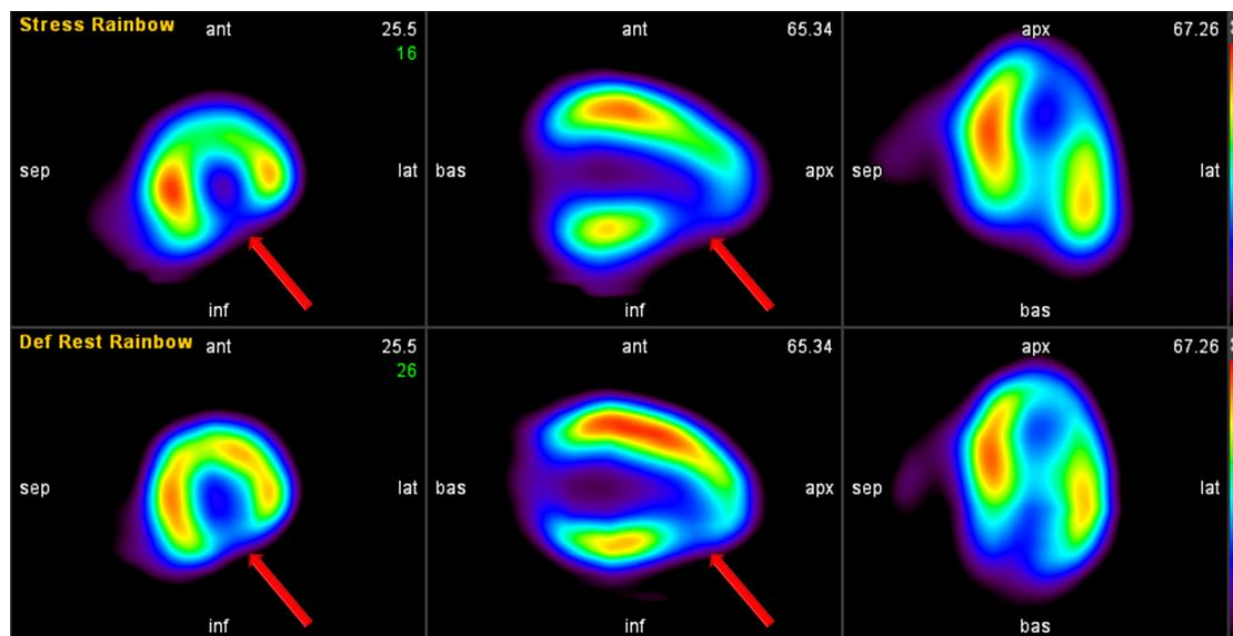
MP SPECT image of a patient with myocardial ischemia. The top and the bottom views show images acquired at stress and rest, respectively. The arrow shows decreased blood flow (reversibility) at the inferior wall in the stress image at the place of the arrow compared to the rest—a typical sign of myocardial ischemia.
